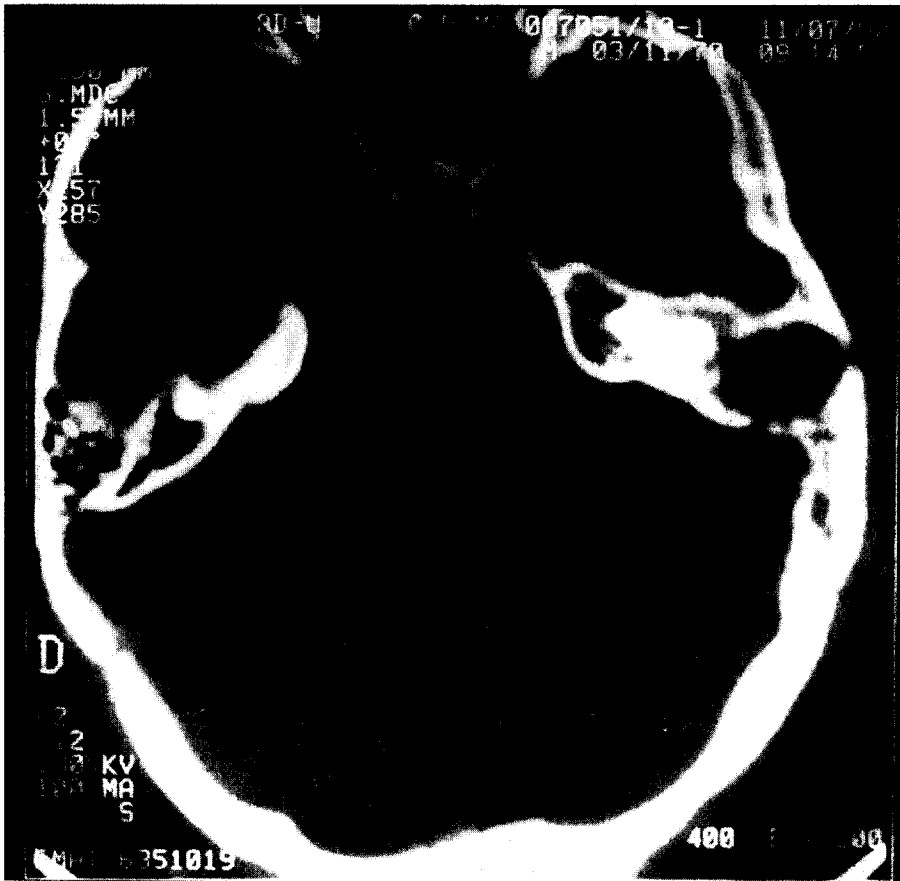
A post-operative CT scan of the temporal bone which shows the relapse of granuloblastic sarcoma in the wide residual middle ear cavity (2 months after surgical intervention).
